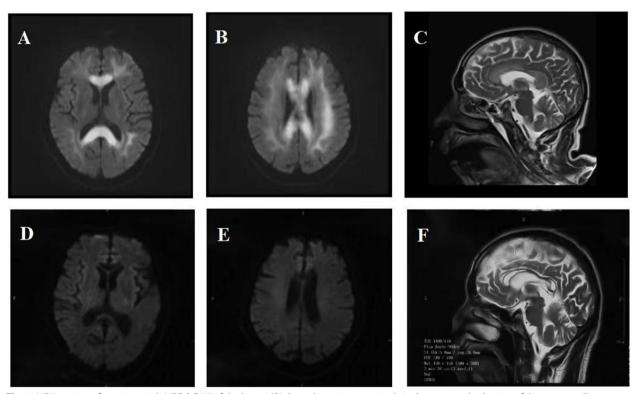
MRI imaging of a patient with MBDA DWI of the brain MRI shows hyperintense signals in the genu and splenium of the corpus callosum five days after MBD onset; B DWI of the brain MRI shows hyperintense signals in the periventricular white matter five days after MBD onset; C Sagittal T1-weighted MRI shows swelling of the splenium of the corpus callosum five days after MBD onset; D DWI of the brain MRI shows hypointense signals in the genu and splenium of the corpus callosum 84 days after MBD onset; E DWI of the brain MRI shows isointense signals in the periventricular white matter 84 days after MBD onset; F Sagittal T1-weighted MRI shows atrophy of the splenium of the corpus callosum 84 days after MBD onset
